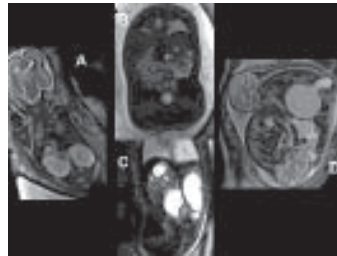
A-D, Fetal MRI of Urogenital System. A is a case of Multicystic kidneys with coronal section showing both kidneys enlarged and markedly hyperintense due to presence of multiple small cysts. There is associated oligohydramnios. Figure 7 B is a fetus with crossed fused ectopia. The coronal section demonstrates fusion of lower pole of one kidney and the superior pole of the other kidney. The fused kidneys are located in the pelvis. Figure-7 C, a case of Unilateral pelviureteric junction obstruction with coronal image depicting a large septated thin walled fluid-intensity lesion in the left retroperitoneum representing a dilated pelvicalyceal system secondary to a pelviureteric obstruction. Figure 7 D is a case of posterior urethral valves in Twin gestation. The sagittal section shows urinary bladder and posterior urethra dilated in the twin on the left side of the maternal abdomen. The urinary bladder in the other twin is normal in size.
